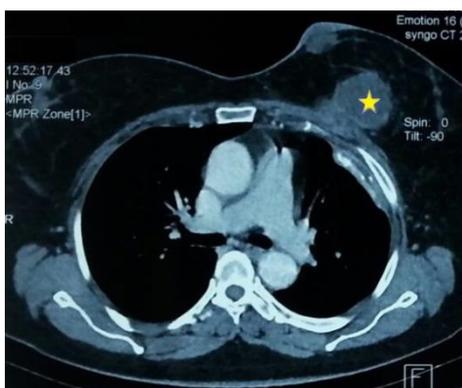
CT scan showing a cystic nodule of left breast, invading anterior wall of the thorax (star)
